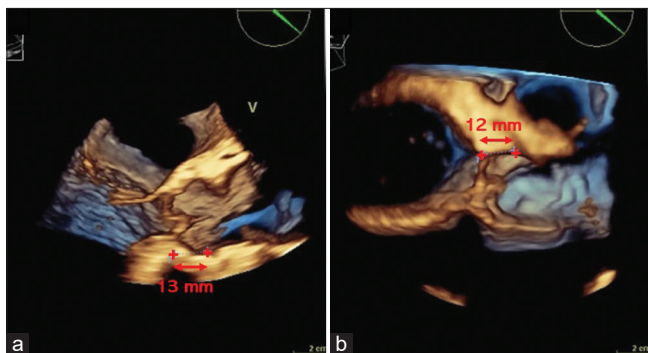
Three-dimensional transesophageal echocardiography for the measurement of coronary ostial height from the aortic annulus. (a) Right coronary ostial height, (b) Left coronary ostial height
